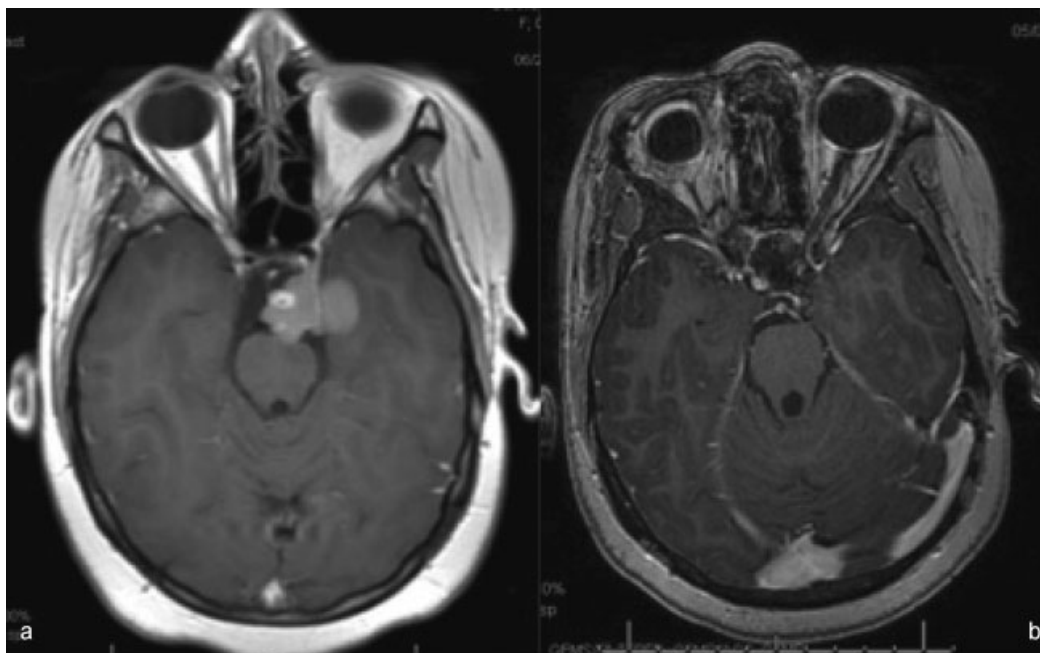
Axial preoperative (a, [left]) and postoperative (b [right]) enhanced T1-weighted MRI demonstrating enhancing mixed solid and cystic suprasellar mass with postoperative gross total resection. MRI, magnetic resonance imaging.
